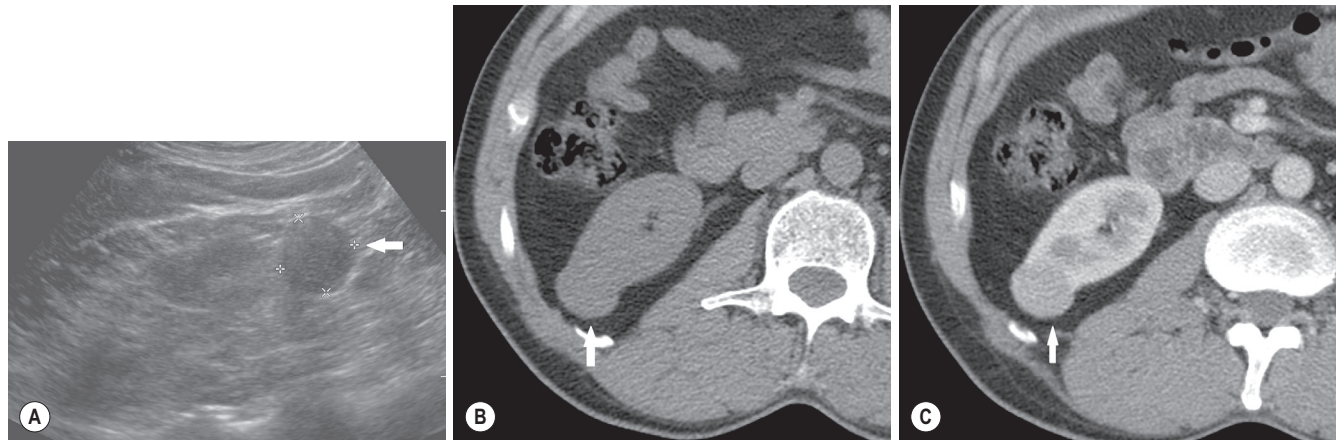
■ Papillary carcinoma of the kidney. (A) US and (B) pre- and (C) post-contrast CT demonstrate an incidental solid mass detected on US which demonstrates low-grade enhancement (25 HU) post-contrast (see arrow). This appearance is typical for a papillary tumour. These can be multifocal, and close scrutiny of the ipsi- and contralateral kidney is recommended.
